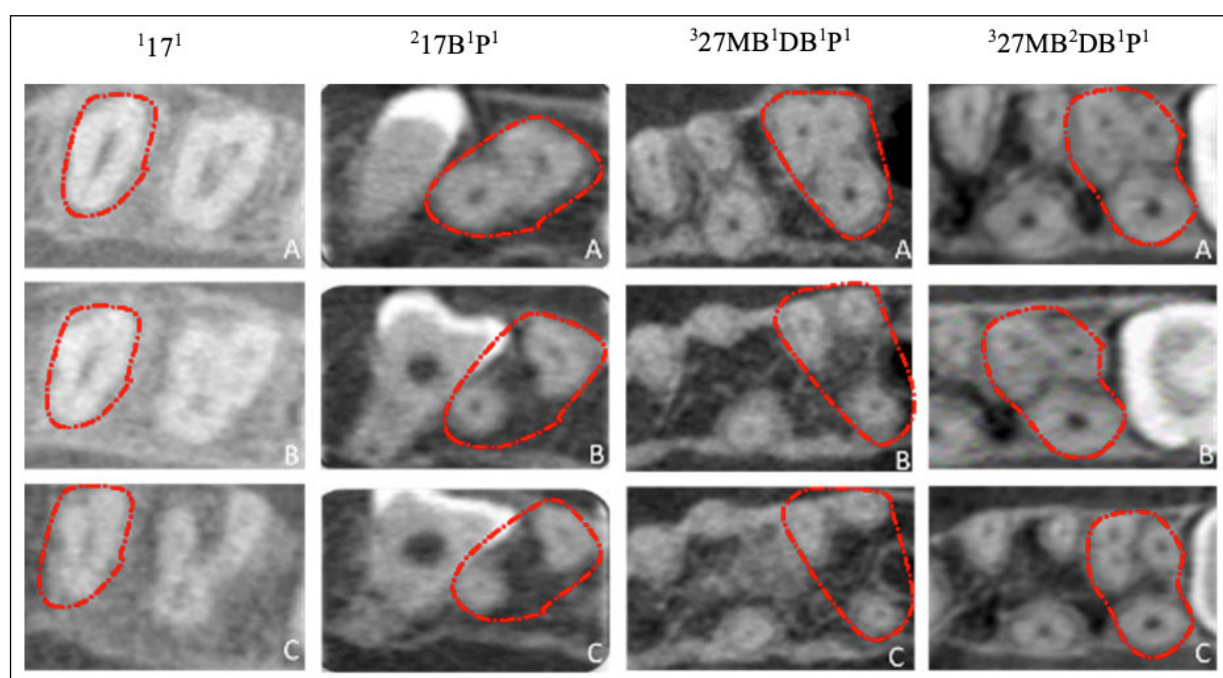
CBCT axial view in coronal (A), Middle (B) and apical (C) thirds showing root canal morphology according to Ahmed et al¹⁷ classification for one, two and three rooted maxillary molars.
